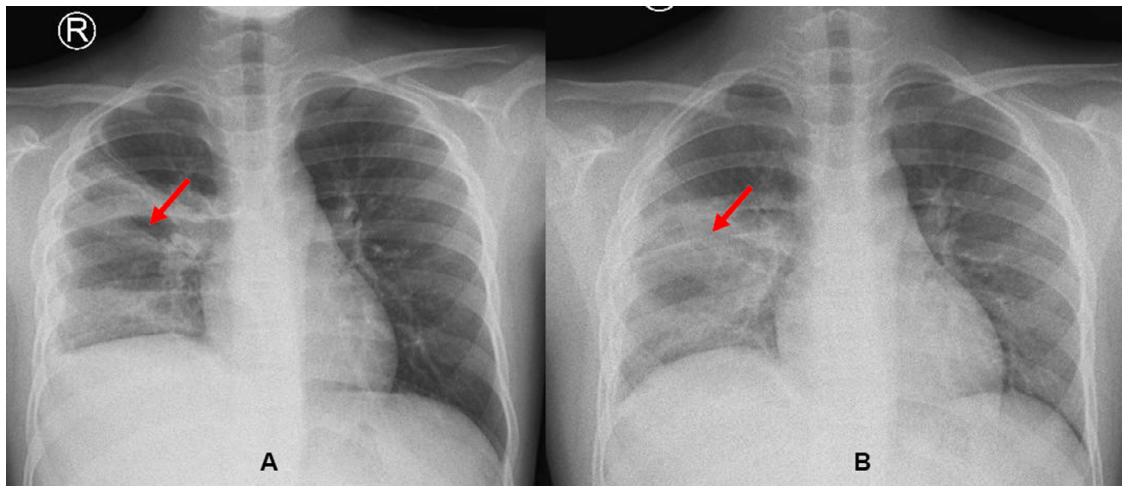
Follow-up chest radiographs at 14th day (A) and h 36th day (B) after the diagnosis showed the improvement at right pulmonary opacity (arrow) and right pleural effusion.
